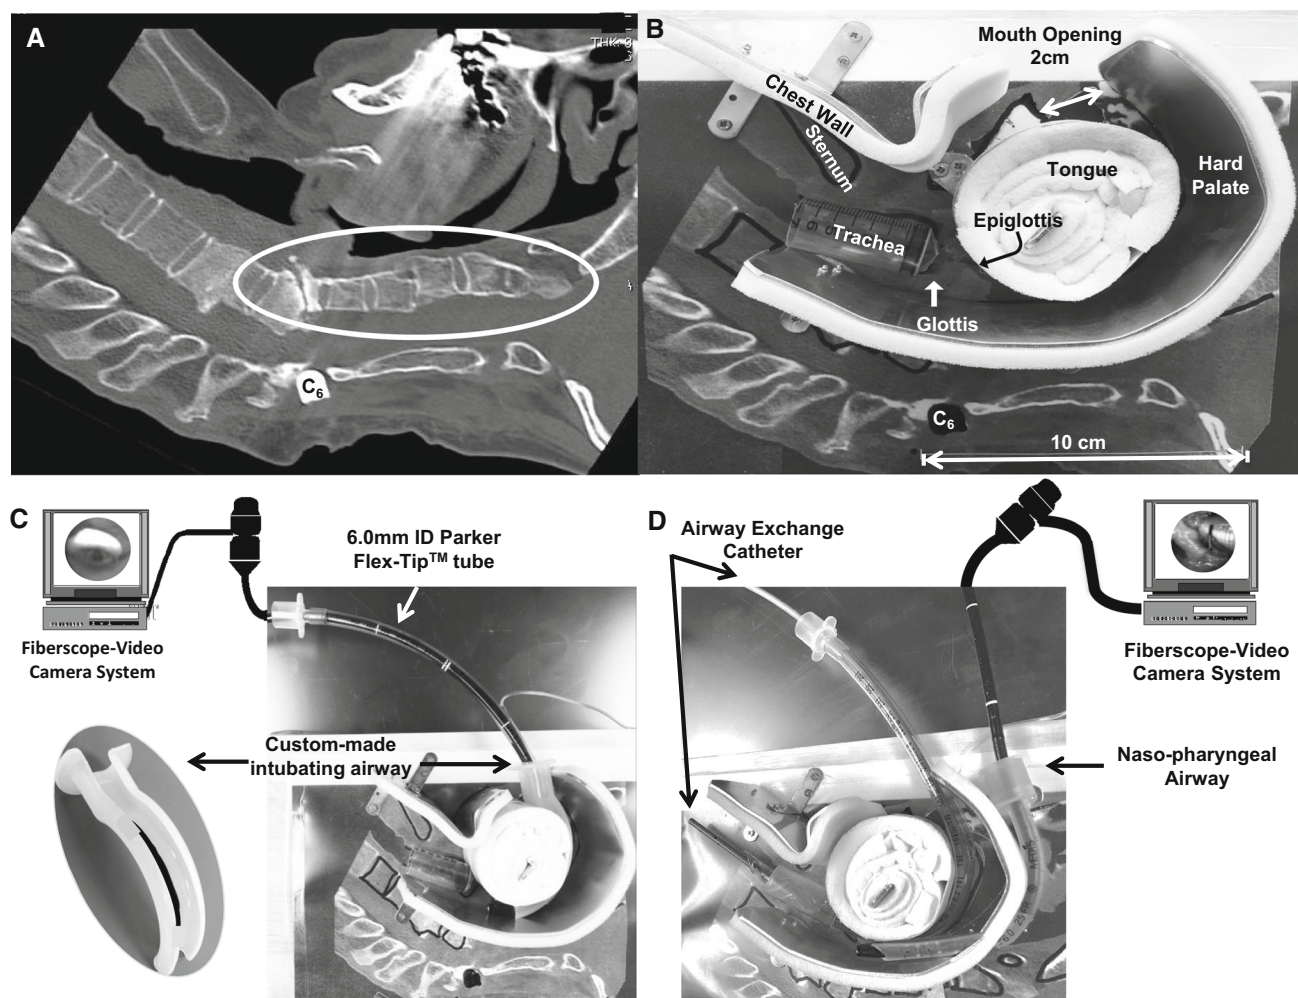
Figure A) Computed tomography (CT) of the cervical spine and upper airway. The first through fifth cervical vertebrae are fused (circle). The head and neck cannot be extended because of a fixed cervical flexion deformity. B) An upper airway model fashioned from CT data of the patient's airway anatomy. C) Tracheal intubation using a fibroscope-video camera system. A fibroscope attached to a video camera monitor system, passed into a 6.0-mm internal diameter endotracheal tube, is inserted through the custom-made intubating
